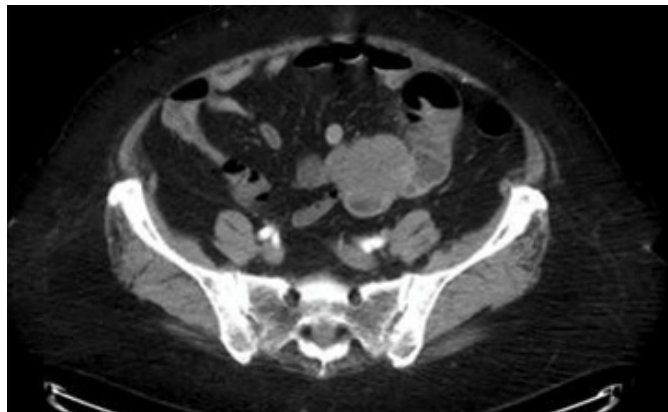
CT abdomen/pelvis with IV contrast demonstrating mass-like lesion with associated bowel obstruction.
